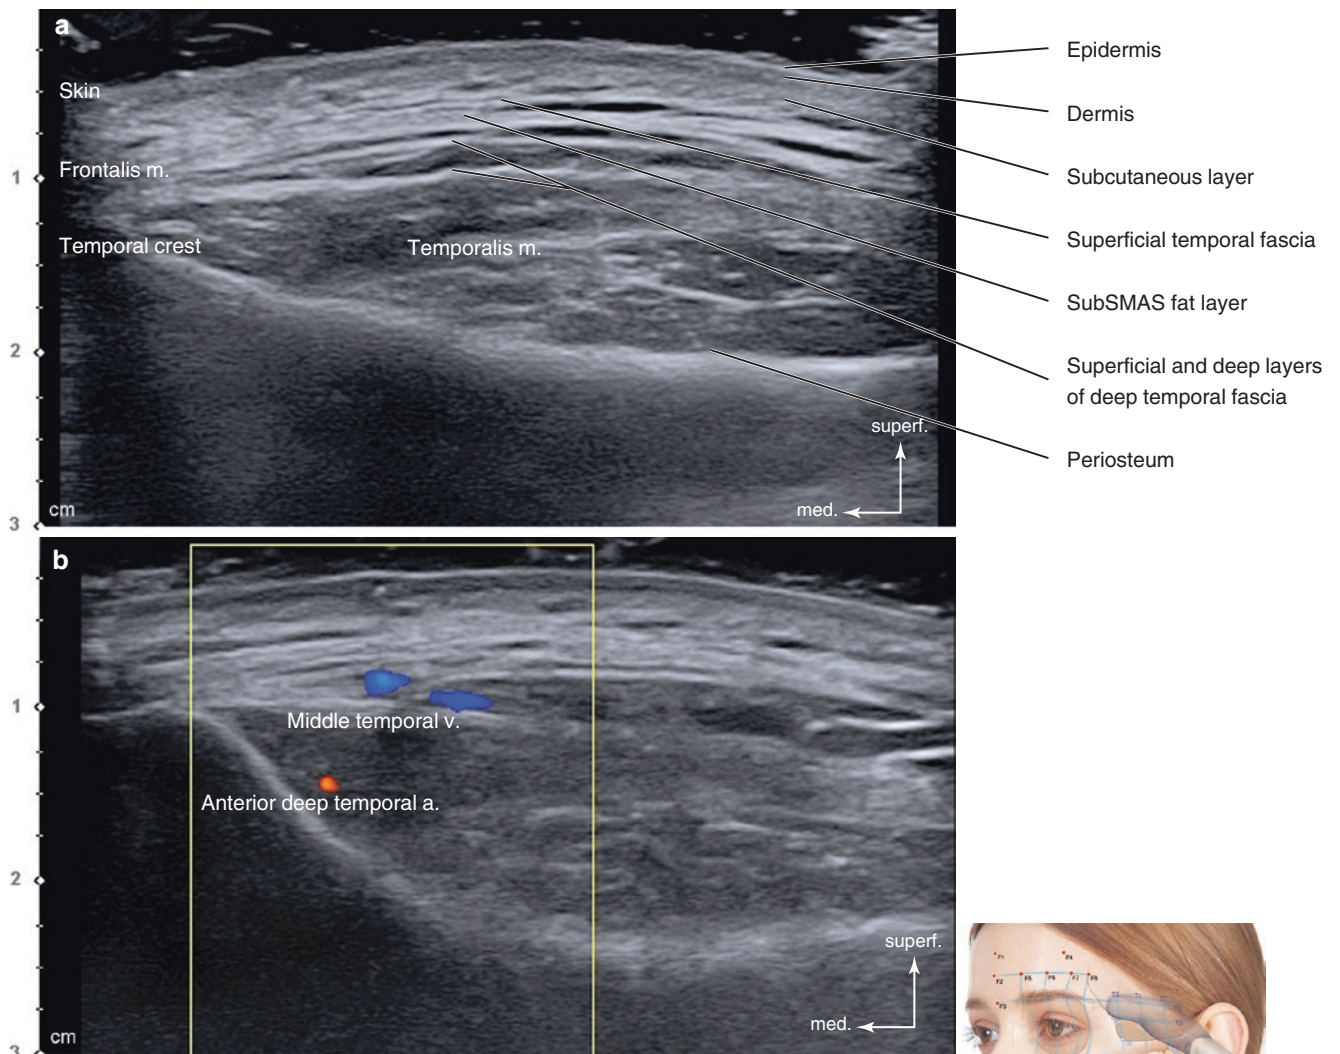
Ultrasonography of the transverse line passing the eyebrow (T1). (a) B mode (transverse view, 15 MHz by linear transducer) and (b) Doppler mode (transverse view, 15 MHz by linear transducer). (Published with kind permission of © Hee-Jin Kim 2020. All Rights Reserved)
